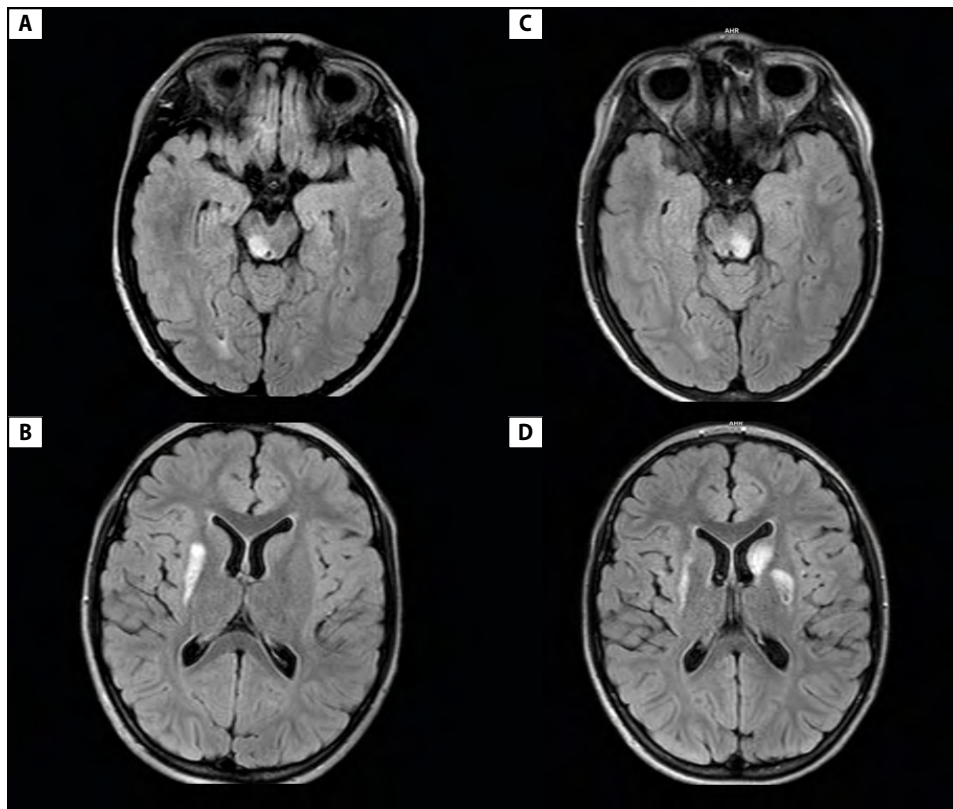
Brain MRI images from patient with DNAJC30-associated Leigh Syndrome treated with idebenone. Brain MRI axial views performed at baseline demonstrate signal intensity changes on FLAIR sequences in midbrain (A) and right lenticular nucleus (B). Control axial views performed after nine months of idebenone therapy show novel contralateral hyperintensities in midbrain (C), head of left nucleus caudate, and left putamen (D). Novel alterations show diffusion restriction corresponding to active lesions
